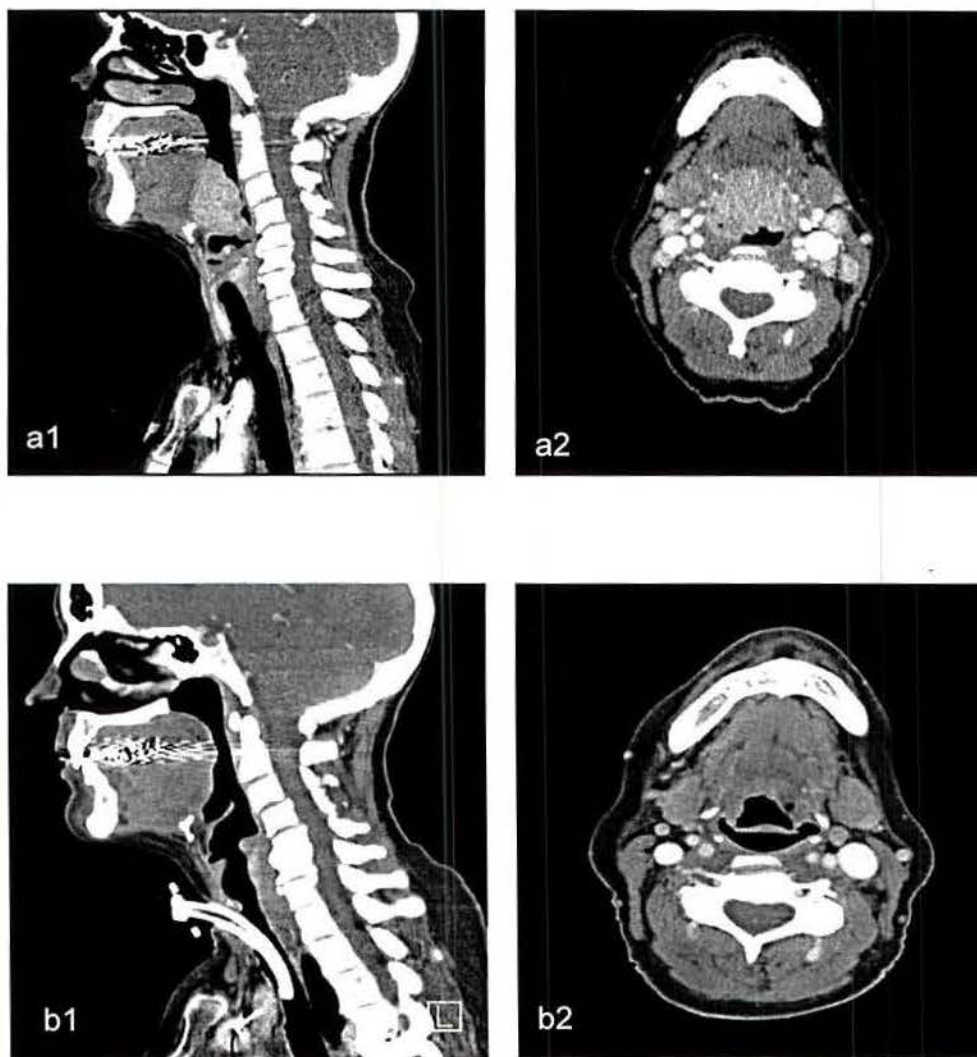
Interval change in size of BOT mass on contrasted CT scan of the head and neck before (a1 and a2) and after (b1 and b2) two cycles of Bendamustine and Rituximab.
